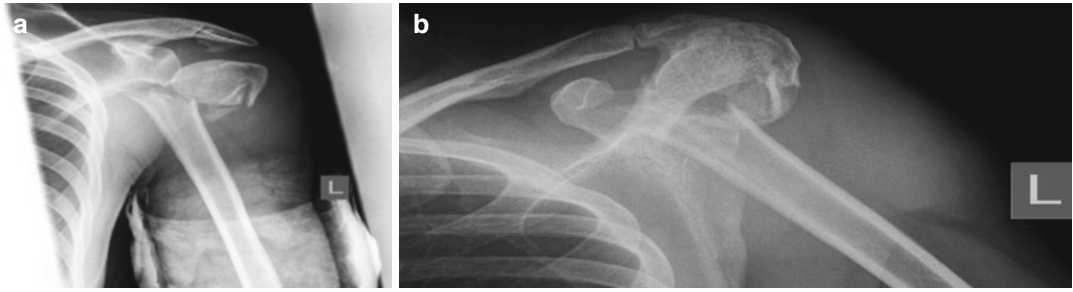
A 39-year-old right-hand dominant female sustained an isolated left shoulder injury. X-rays (a) AP and (b) Velpeau views are shown
